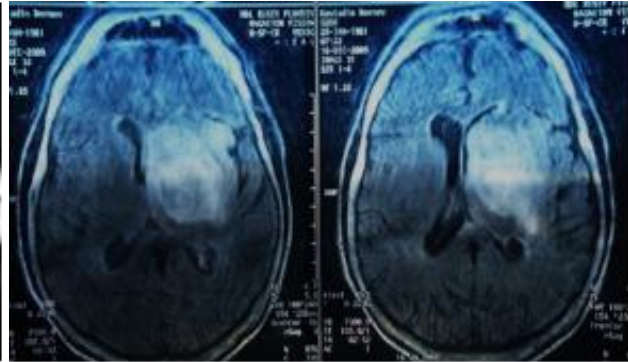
MRI image of glioma affecting the left basal ganglia
